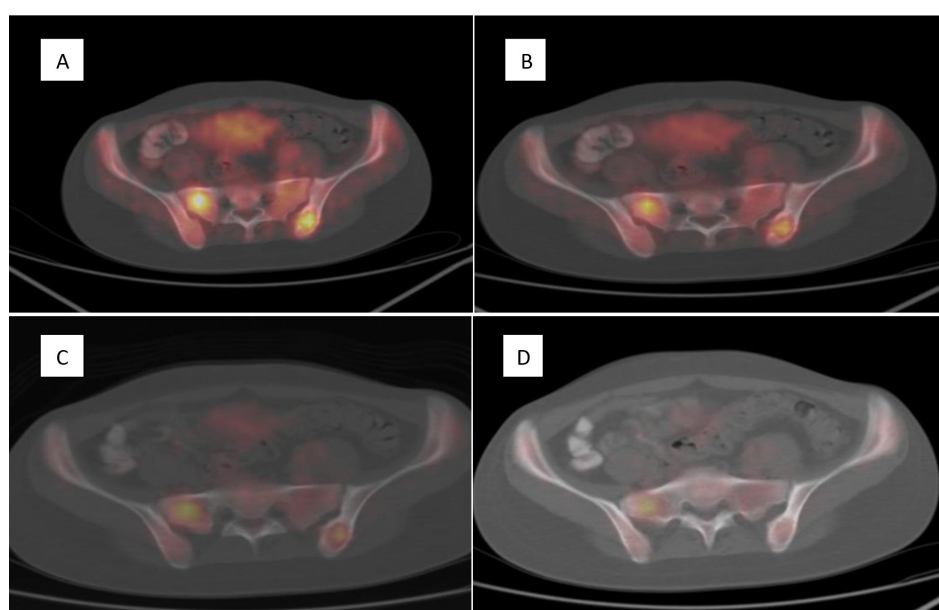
18F-FDG-PET-CT in a 20-year-old woman who presented with pain in the right groin and loin for 3 months and was diagnosed with tuberculosis of the left ilium and right sacrum showing (A) increased uptake before the start of ATT [SUVmax 10.4] and (B) decreased uptake at 2 months [SUVmax 2.8], (C) 6 months [SUVmax 1.6], and (D) after completion of ATT at 12 months with SUVmax 0.6
